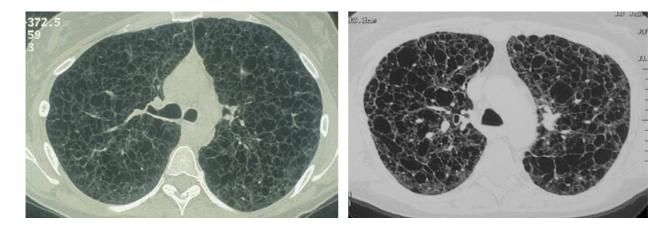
High resolution axial CT image of the chest of a patient with LAM. Note diffuse involvement of the lung parenchyma, with numerous thin-walled cysts.
